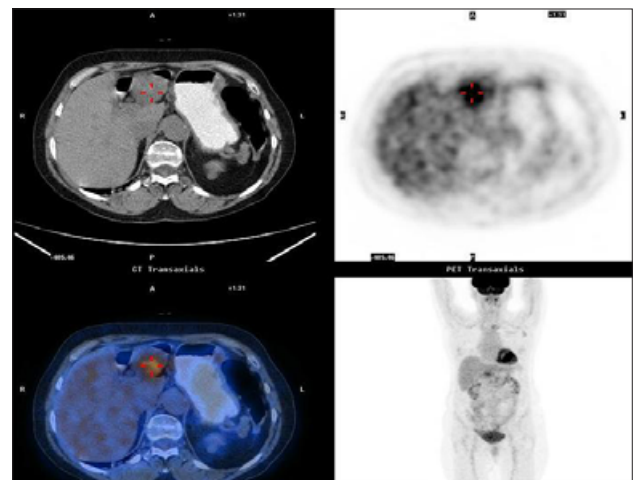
The transaxial PET-CT images showed an increased FDG uptake (SUVmax = 5.1) in the mass lesion in the left lobe of liver.
